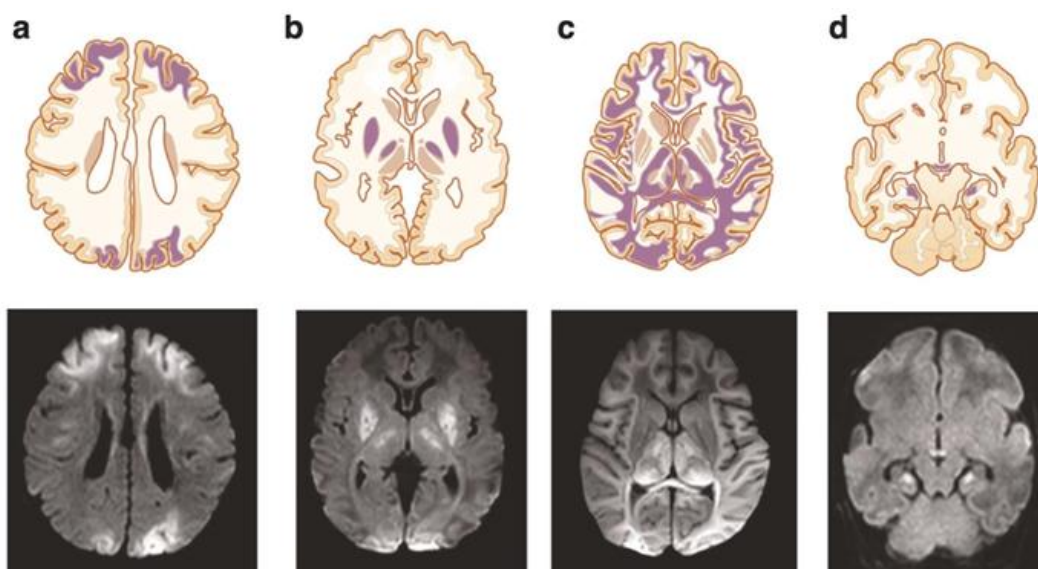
Magnetic Resonance Imaging (MRI) and axial MRI-diffusion weighted images of infants with hypoxic-ischemic encephalopathy taken during the first days of life, portraying common injury patterns. The images below, from left to right, portray a) bilateral watershed injury; b) basal ganglia/thalamic injury; c) near total injury; d) injury of mammillary bodies and hippocampi [13].
